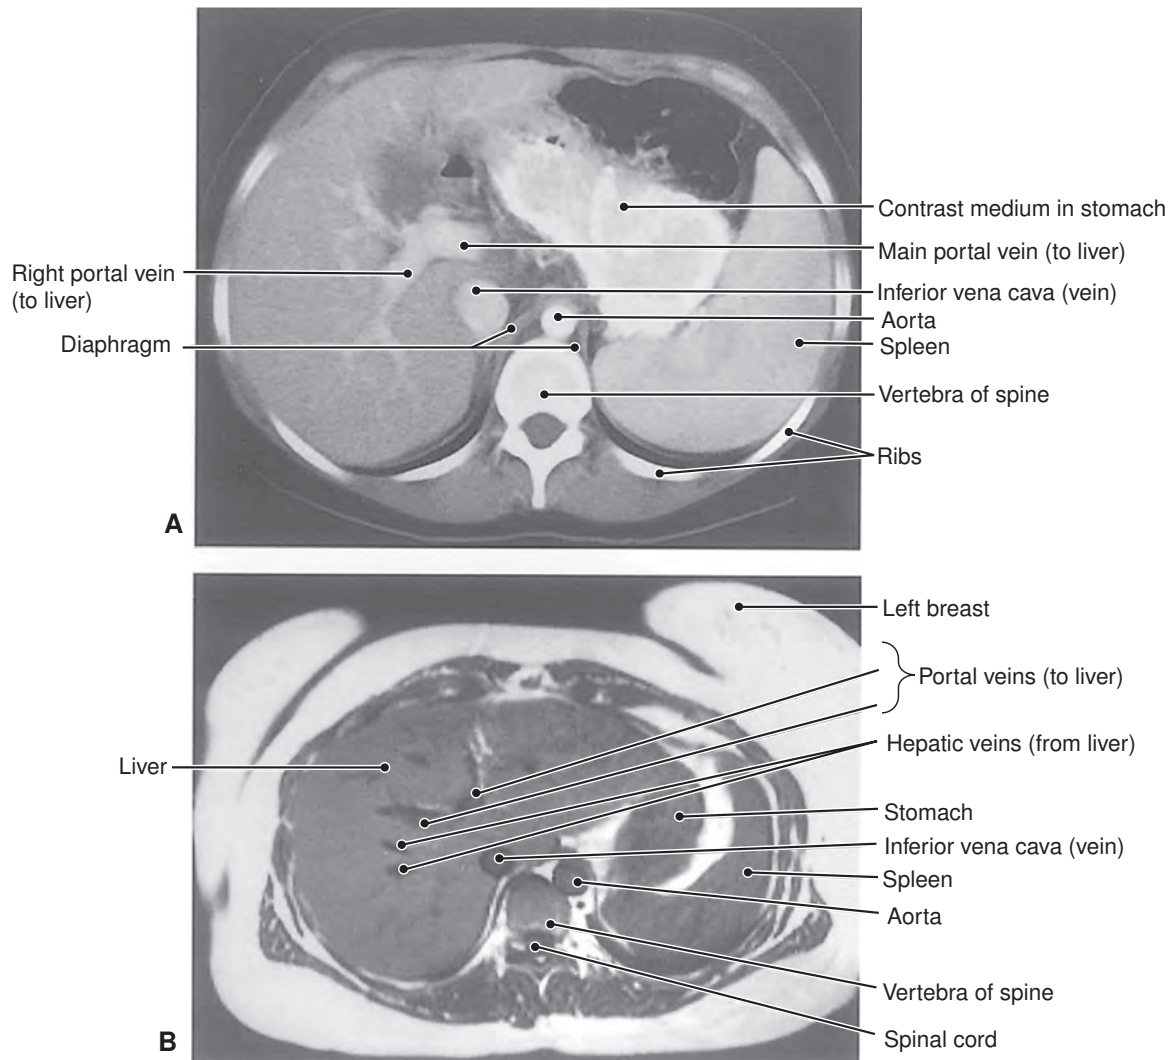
Imaging techniques. Shown are cross sections through the liver and spleen. A. Computed tomography (CT). B. Magnetic resonance imaging (MRI).
